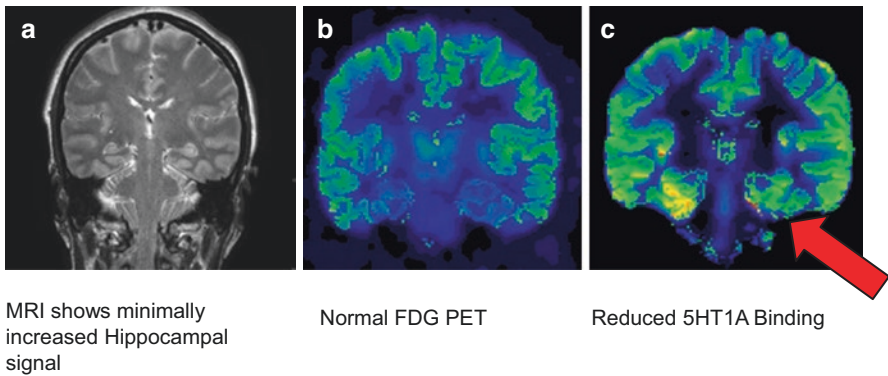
A 44-year-old patient with a history of drug-resistant seizures; surface electroencephalography revealed left temporal seizure onset. (a) Normal MRI result. (b) Normal ^{18}F FDG-PET result. (c) ^{18}F FCWAY PET shows relatively decreased left temporal ^{18}F FCWAY binding, indicating reduced 5HT1A receptor availability. Reproduced from Theodore et al. *Journal of Nuclear Medicine* 2012; 53:1375–1382
